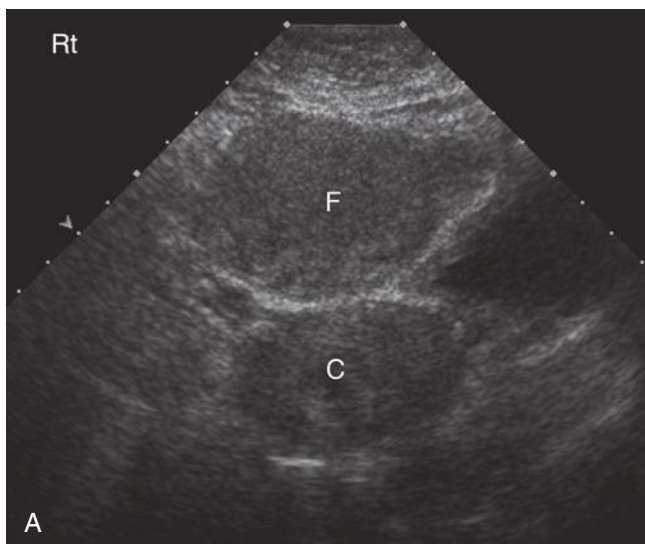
A, Transverse axial sonogram of the pelvis in a nongravid patient. There appears to be either a duplication of the uterus or the uterus and an adjacent mass (C, F). Rt, right. B, A sagittal scan demonstrates that what was seen in the transverse scan was the cervix (C) and fundus (F) of an anteverted uterus. The dashed line represents the plane of section in A. H, head.
